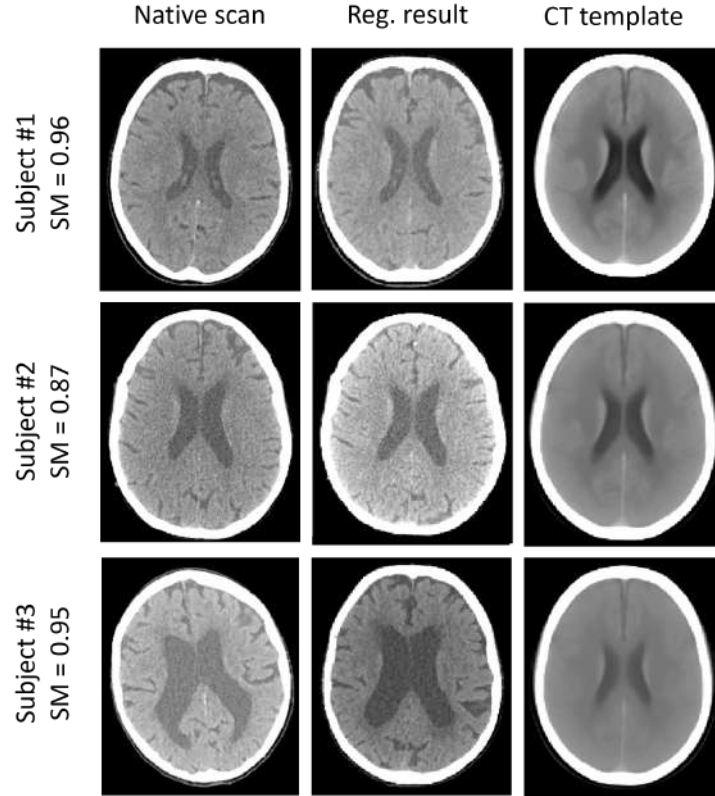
Three qualitative registration results from Dataset 1. Affine registration of native scans to the study-specific CT template.
